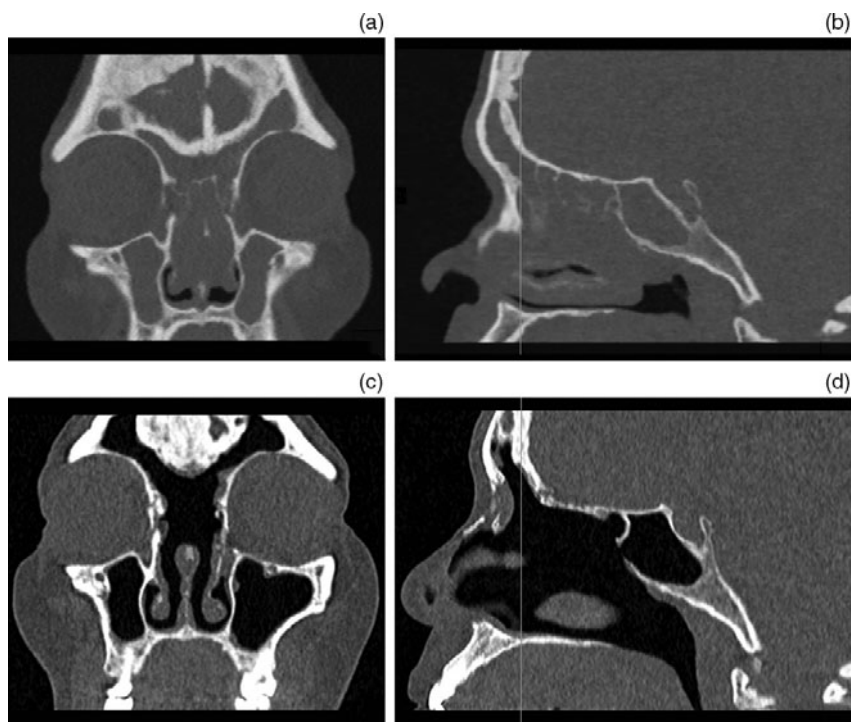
Pre-operative (a) coronal and (b) sagittal and post-operative (c) coronal and (d) sagittal computed tomography scans of a 60-year-old woman with non-steroidal anti-inflammatory drug exacerbated respiratory disease who underwent large cavity functional endoscopic sinus surgery for uncontrolled chronic rhinosinusitis with nasal polyps.
